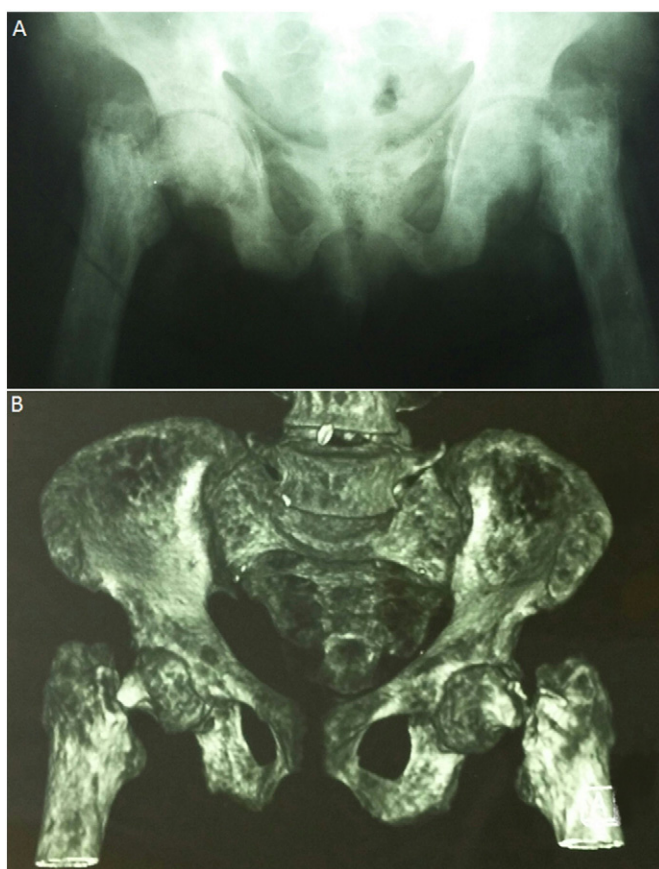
(A) X-ray images showing poor bone quality and deformity on both hips; (B) computed tomography image of the pelvis clearly demonstrating displaced fractures of both femoral necks.
